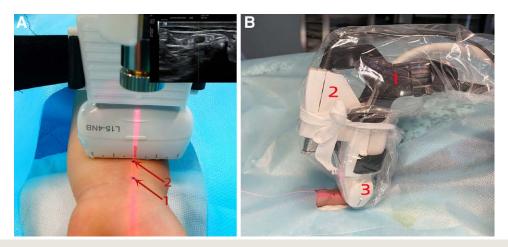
(*A*) The probe was placed 1 cm below the second wrist striae of the child, and the ultrasound midline passed through the middle of the artery's cross-section (for details, see sonogram at *upper right*). A sterile marker was used to mark point 1 below the ultrasound probe midline marker. Then, the probe was moved to the proximal end 1.5 cm, and point 2 was marked again with the same method. (*B*) Side view of single-operator laser-assisted ultrasound-guidance system: the probe fixed arm (1), the laser device (2), and the ultrasonic probe (3).
